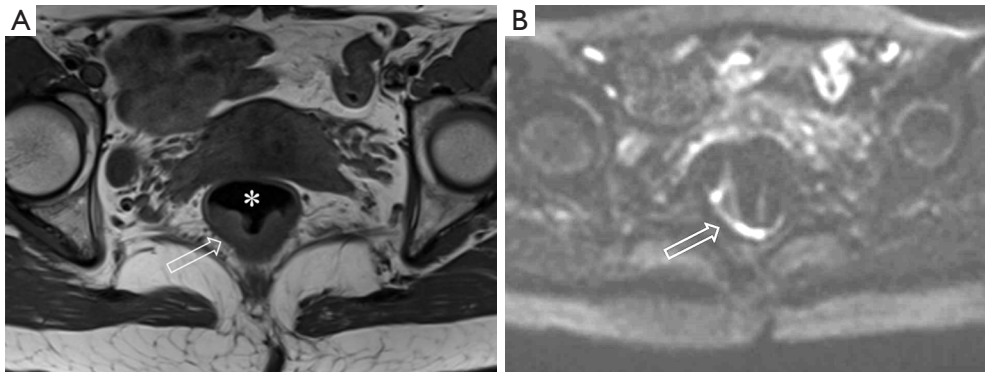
A 51-year-old woman with low RC. (A) Axial MR rectography shows the tumor (short arrow) and the air in the rectum (asterisk) at the T2WI; (B) axial DWI shows the tumor (arrow) is distorted due to air-tissue interface susceptibility artifact. RC, rectal cancer; DWI, diffusion weighted imaging.
